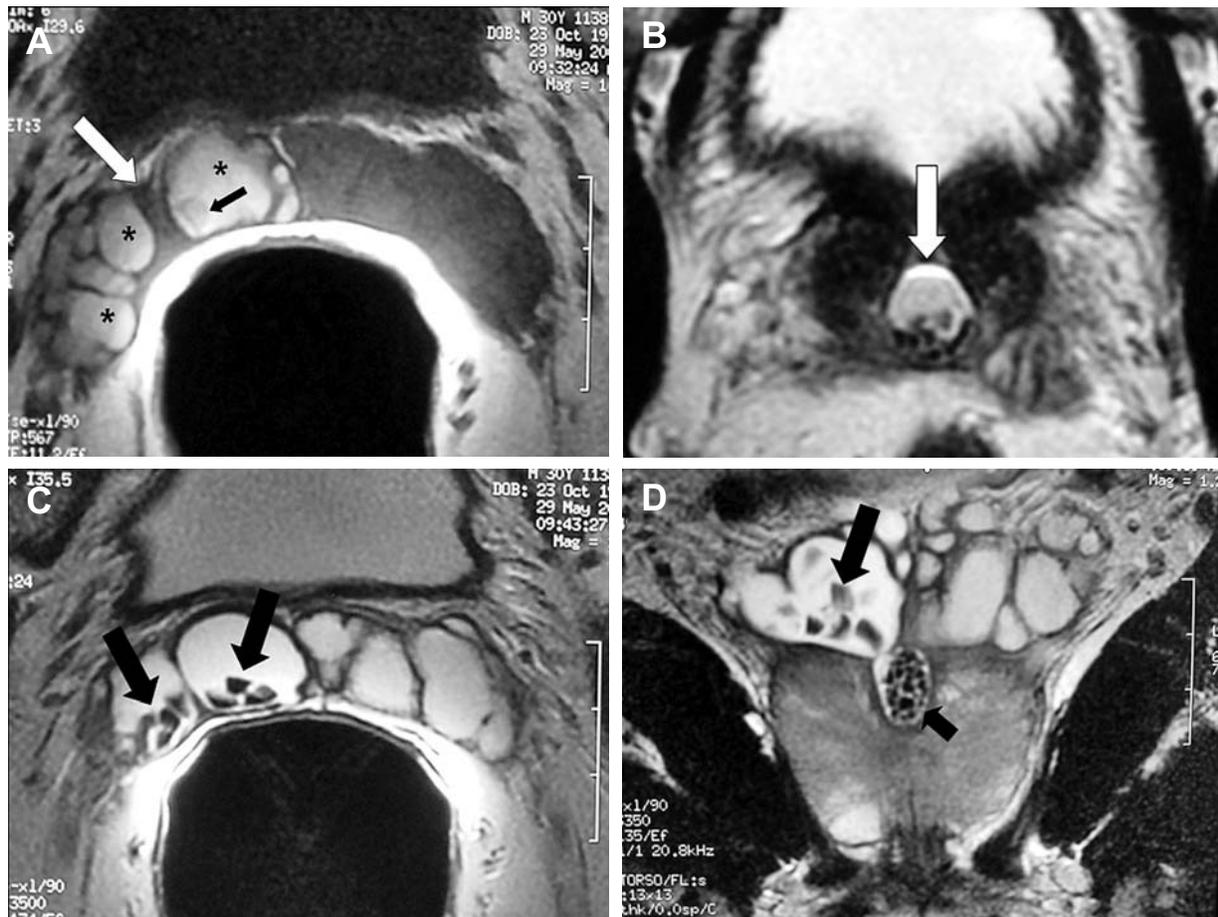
Hemorrhagic seminal vesicle associated with calculi within the right seminal vesicle and dilated ejaculatory duct. A 30-year-old man, with history of persistent hemospermia and ejaculatory pain. A) E-MRI, axial plane, T1-weighted image, showing a hemorrhagic dilated ejaculatory duct (white arrow), containing blood (asterisk) and calculi (black arrow). B) E-MRI, axial, T2-weighted image, better shows the calculi within the dilated ejaculatory duct (arrow). C) and D) E-MRI, axial and coronal T2-weighted images respectively, nicely demonstrates the presence of several stones within the right seminal vesicle (arrows) and within the dilated right ejaculatory duct (small arrow). Note the contiguity of the dilated seminal vesicle with the dilated right ejaculatory duct. This is an essential finding for the differentiation between dilated ejaculatory cyst from midline prostatic cyst.
